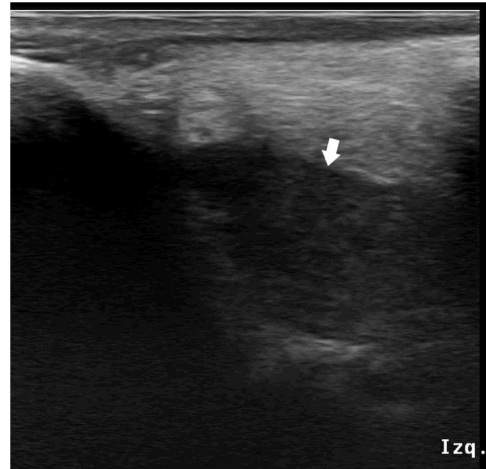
Ultrasound of orbits. Image showing a homogeneous, hypoechogenic mass, well demarcated against the orbital fat (arrow), located in the left orbital roof.
